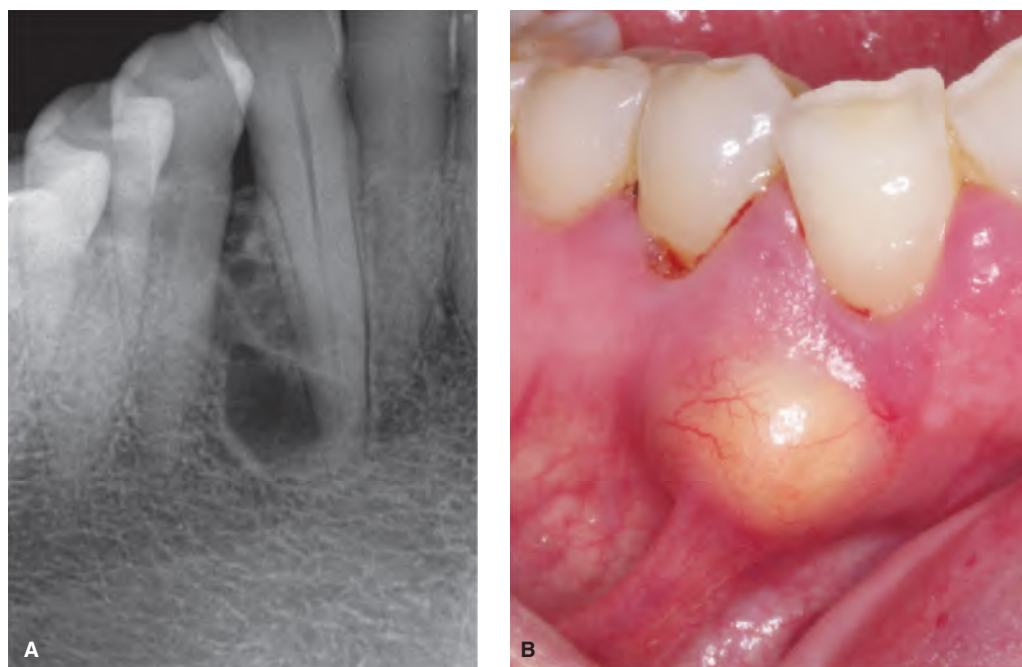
A. Periapical radiograph showing a multilocular radiolucency. B. Clinically, a buccal expansion associated with the intraosseous lesion is noted. Surgical enucleation and biopsy confirmed a diagnosis of *odontogenic myxoma*. Compare this case to the one described in Figure 10-32. The multilocular nature of the process can be suggestive of an odontogenic tumor in general. (Courtesy of Dr. Tomoko Wada, Los Angeles, CA.)
